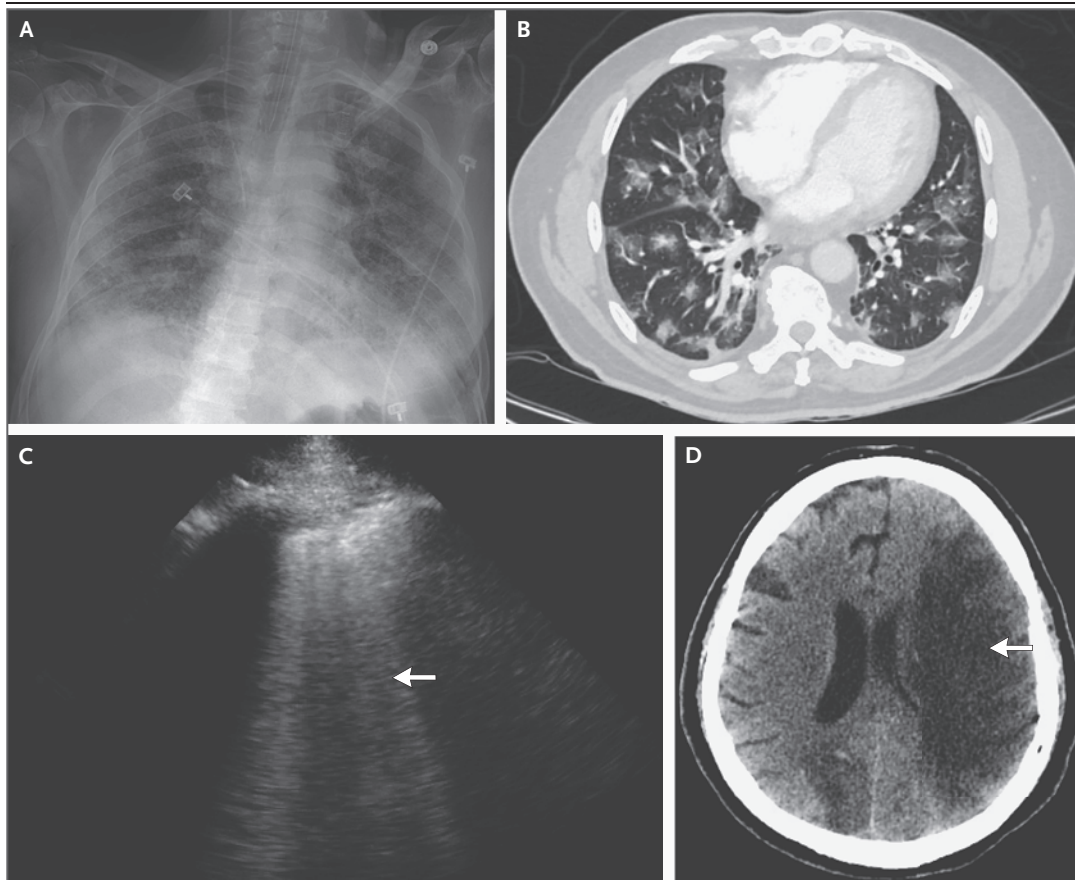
Radiographic and Ultrasonographic Findings of Severe Covid-19.
